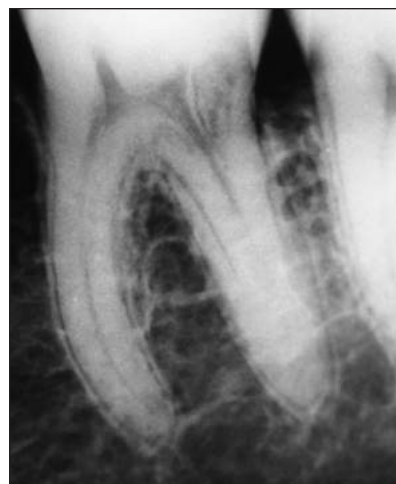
A radiograph taken 10 years after Figure 9A.
